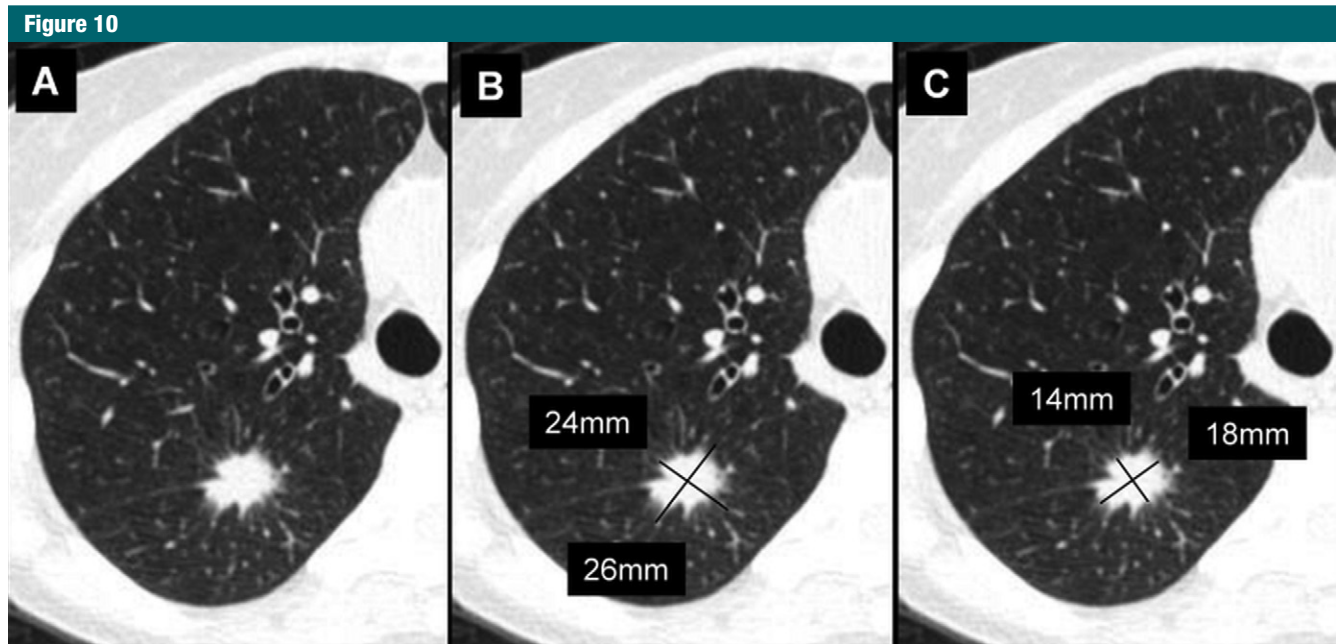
A, Transverse CT section through a spiculated right lung nodule. B, Inclusion of spiculations into the measurement causes substantial overestimation of nodule size. C, The recommended approach is to measure only the solid core.
